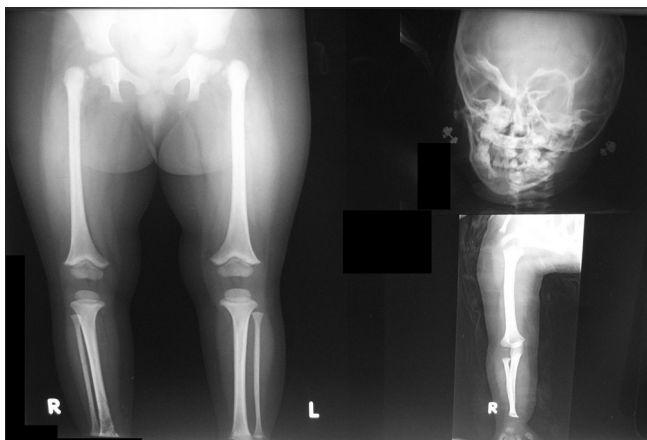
Radiographs of long bone showing cortical thickening with medullary stenosis
